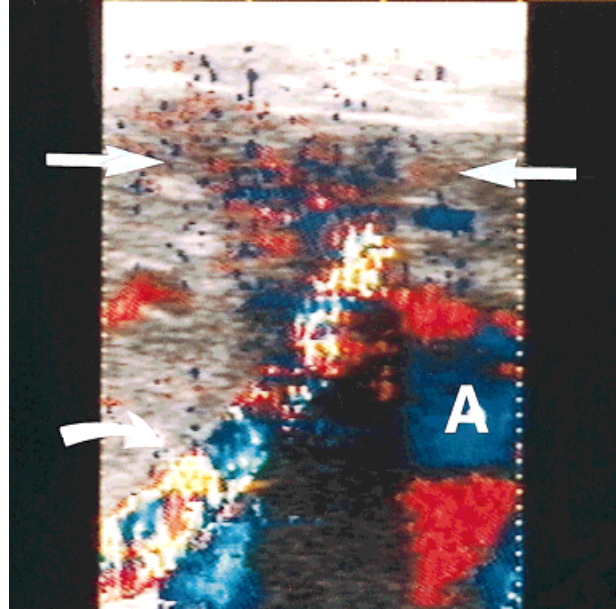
Color Doppler sonogram showing speckling of perivascular liver parenchyma (large arrows) adjacent to the arteriovenous communication. This characteristic finding is due to vibrations transmitted from the fistula to surrounding tissues. The hepatic artery (curved arrow) contains high-velocity turbulent flow. A, aneurysm.
